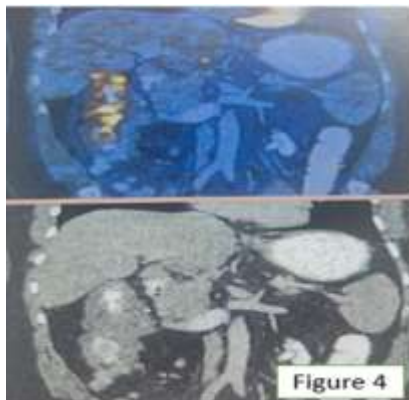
PET CT showing colonic growth
